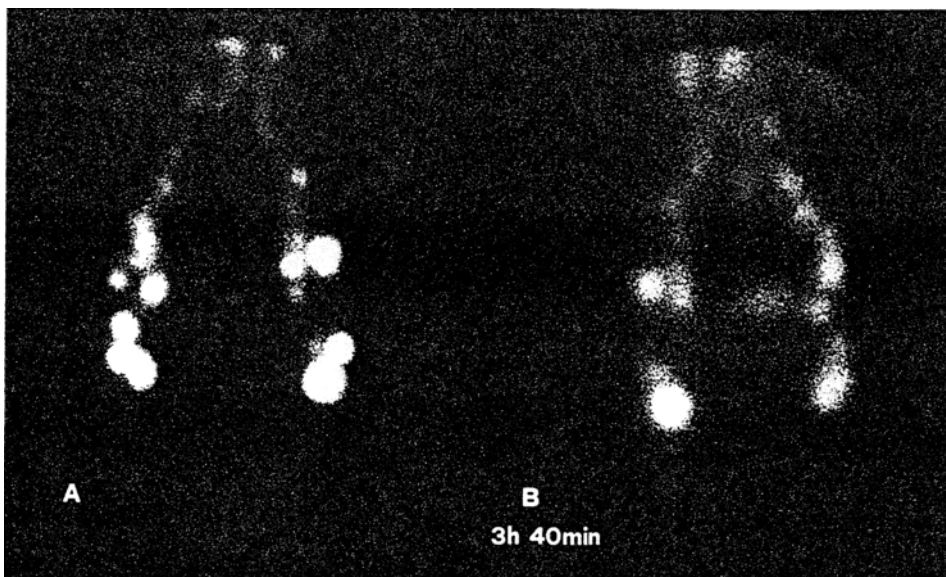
Photoscintigraphy of the iliac and lumbar aortic lymph nodes in the ventral (A) and dorsal (B) projection.
